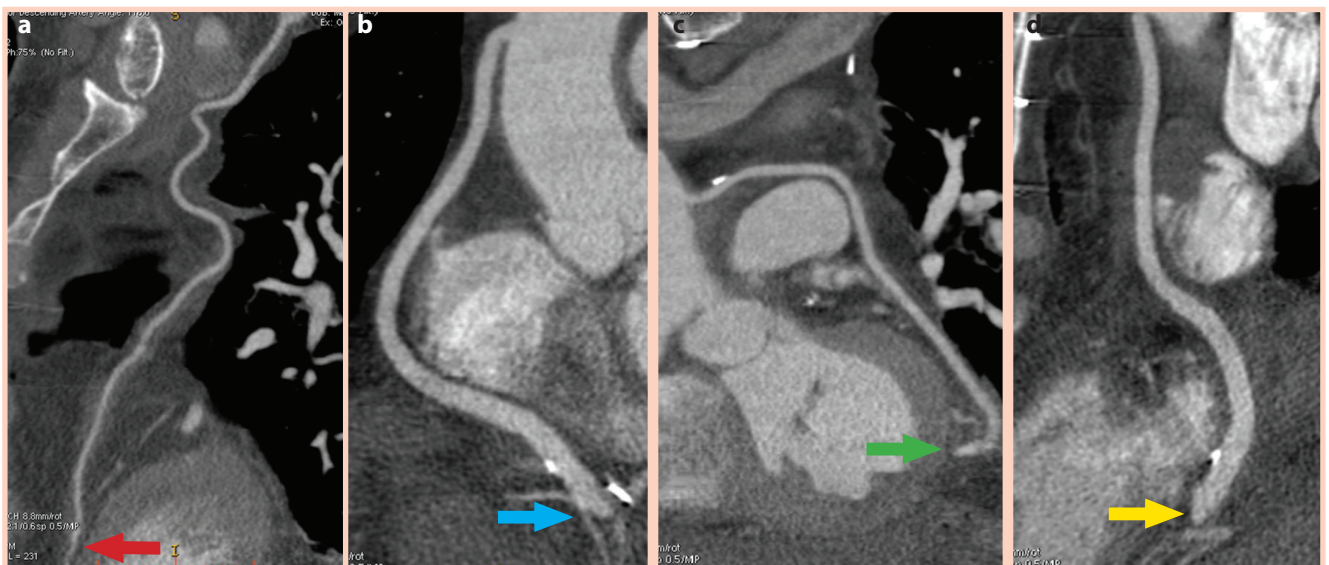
CT angiography imaging of the distal anastomosis of LIMA on LAD (a, red arrow), venous graft on RCA (b, blue arrow), LRA on Cx (c, green arrow), venous graft on Dg1 (d, yellow arrow).
